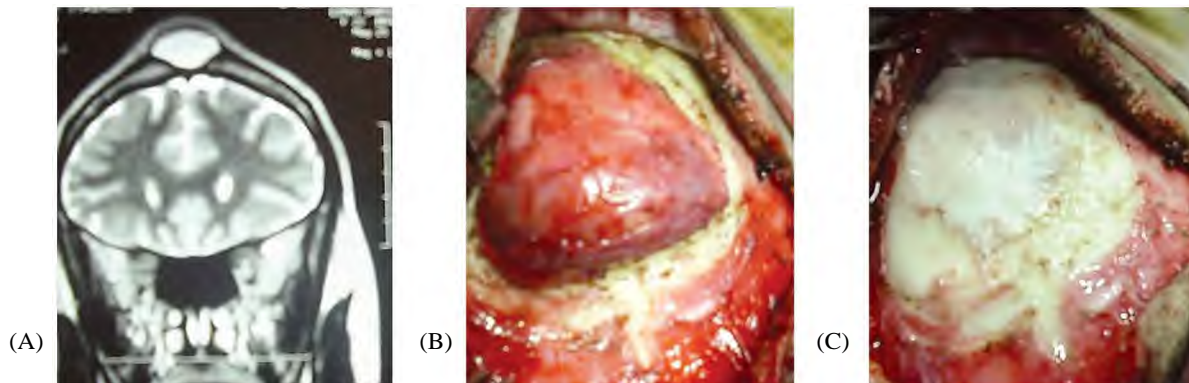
(A) Coronal T2 weighted MRI showing the dermoid cyst and skull defect. (B) Intra-operative image showing the cyst. (C) The view after application of acrylic.
